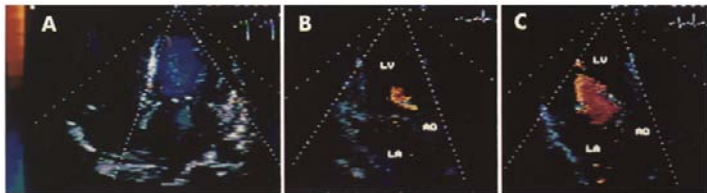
A, Systolic frame from the apical four-chamber view showing mitral regurgitation. The outer border of the largest definable flow disturbance (blue) within the left atrium was traced using computer-assisted planimetry. B, Diastolic frame from the apical long-axis view in a patient with aortic regurgitant flow (red). The outer border of largest red-yellow area seen before mitral opening was traced by computer planimetry to measure the aortic isovolumic jet area. C, Same patient. In a later diastolic frame, the largest area of regurgitant velocity (red-yellow) occurring at any point during diastole was traced to determine the aortic maximal jet area. Ao = aortic root; LA = left atrium; LV = left ventricle.
